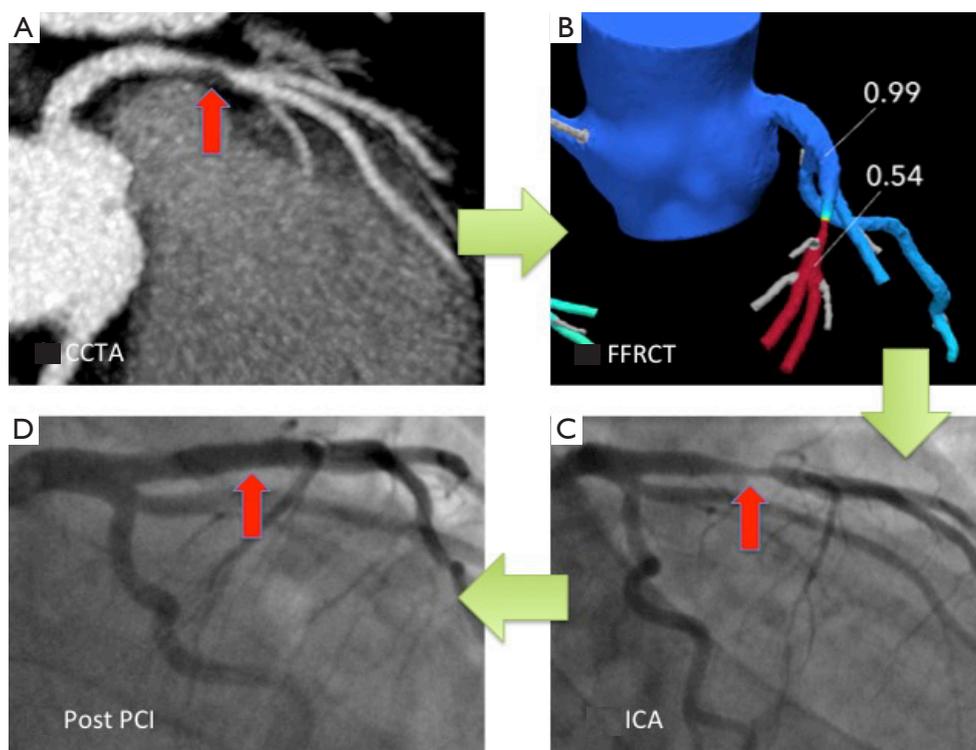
Case example of the clinical utility of flow reserve computed tomography (FFRCT). A 57 years old man with typical stable angina, underwent computed tomography angiography (CCTA) (A) and high grade stenosis identified in the left anterior descending (LAD) artery. CCTA dataset was sent for FFRCT analysis (B) and determined that the lesion was functionally significant. Invasive coronary angiography (ICA) confirmed severe proximal LAD stenosis (C) and the lesion was stented (D).
